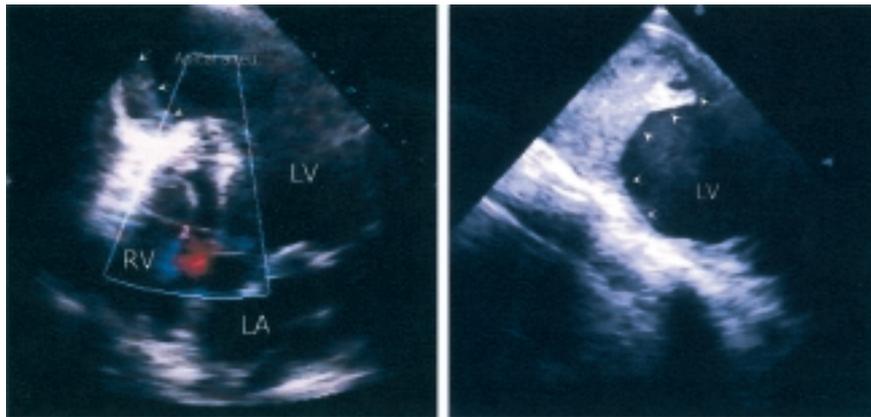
Echocardiography was repeated 8 months after the infarction. Left panel: color Doppler echocardiography of the same view as in figure 2 shows that the left-to-right shunt had completely disappeared; a large apical mural thrombus inside the aneurysm is also evident (arrow). Right panel: a transesophageal echocardiographic image of the modified transgastric view shows that most of the chamber of the apical and septal aneurysm was filled by mural thrombus (arrow). LA = left atrium; LV = left ventricle; RV = right ventricle.
